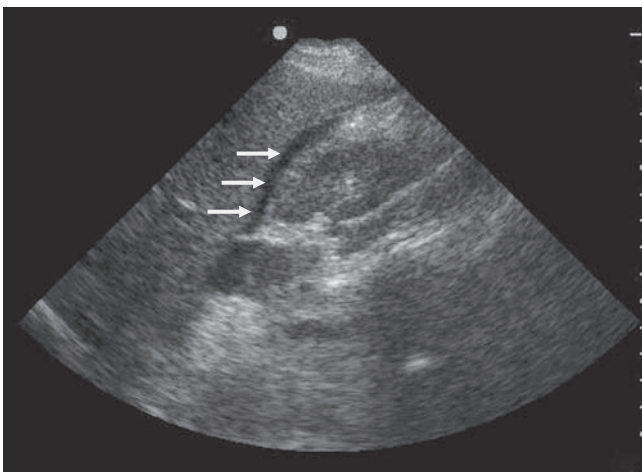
A positive FAST examination. Note the anechoic stripe of fluid (arrows) in Morison's pouch, between the liver and kidney. FAST indicates focused assessment with sonography in trauma.
